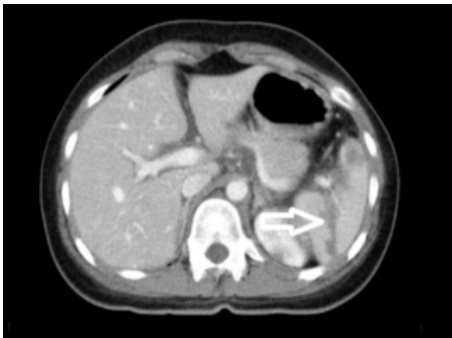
CT image of spleen laceration (grade 3 = >3 cm parenchymal depth or involving trabecular vessel).
